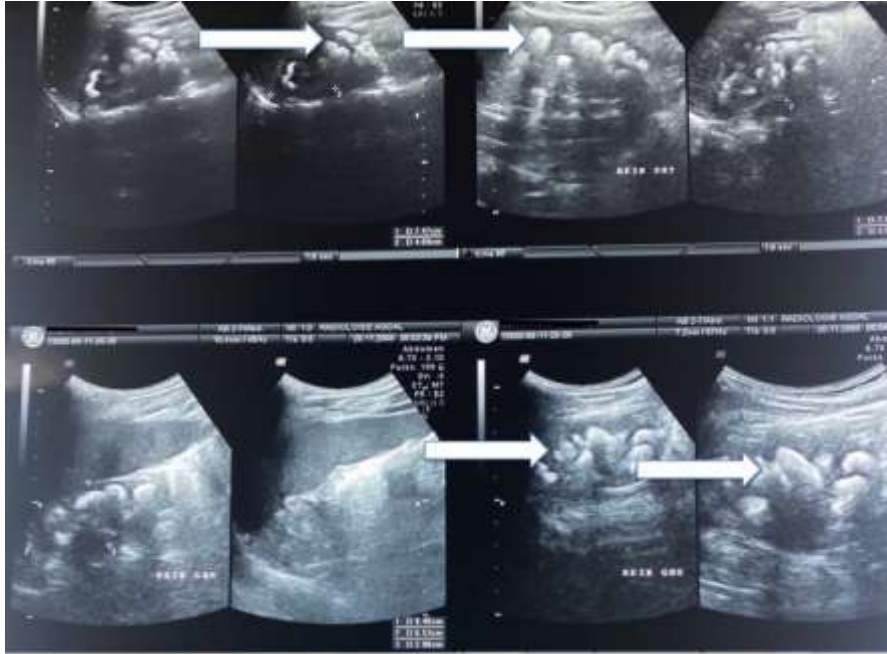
Renal ultrasound showing several hyper-echogenic lithiasis images.
